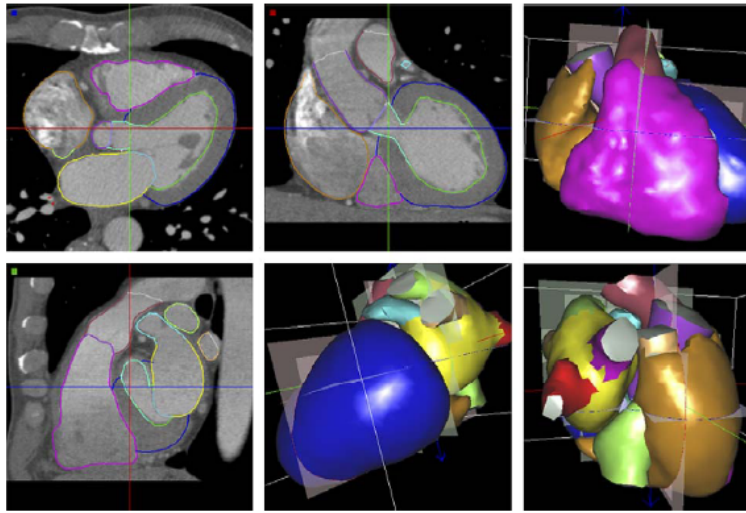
The four-chamber model adapted to a multi-slice CT image. The image shows three orthogonal cut planes and three renderings of the surface model from different perspectives. Image adopted from [95].
